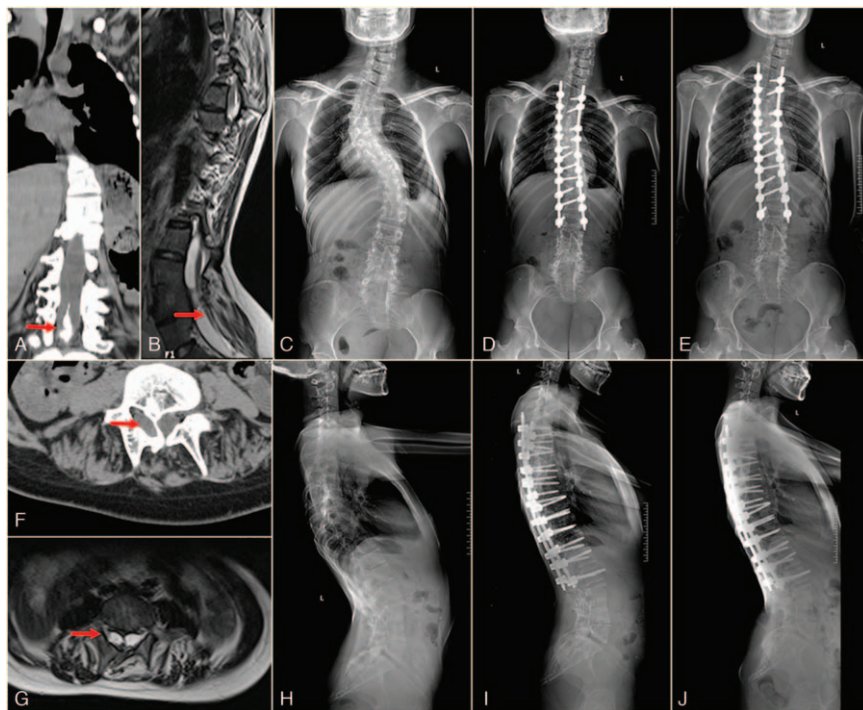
A 18-year-old girl with congenital scoliosis and 2 intraspinal anomalies (coexisting type 1 split cord malformation [SCM] and tethered cord) received posterior correction and instrumentation without preliminary neurosurgical intervention. No neurologic deficits were found before or after surgery. (A) An osseous spur on coronal CT imaging. (B) A tethered cord on sagittal magnetic resonance imaging. (F) A consecutive osseous spur on axial CT imaging. (G) A consecutive osseous spur with the owl sign on axial MRI imaging. Preoperative anteroposterior (C) and lateral (H) views. Postoperative anteroposterior (D) and lateral (I) views. Final follow-up anteroposterior (E) and lateral (J) views.
